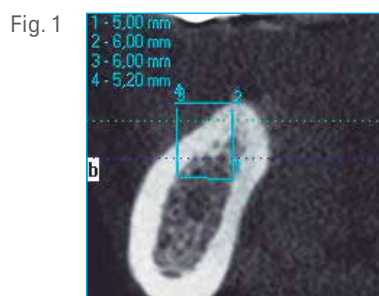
Cone Bean CT scan before the bone graft. A thin alveolar ridge is observed with insufficient width for placement of a 5 mm diameter implant.
